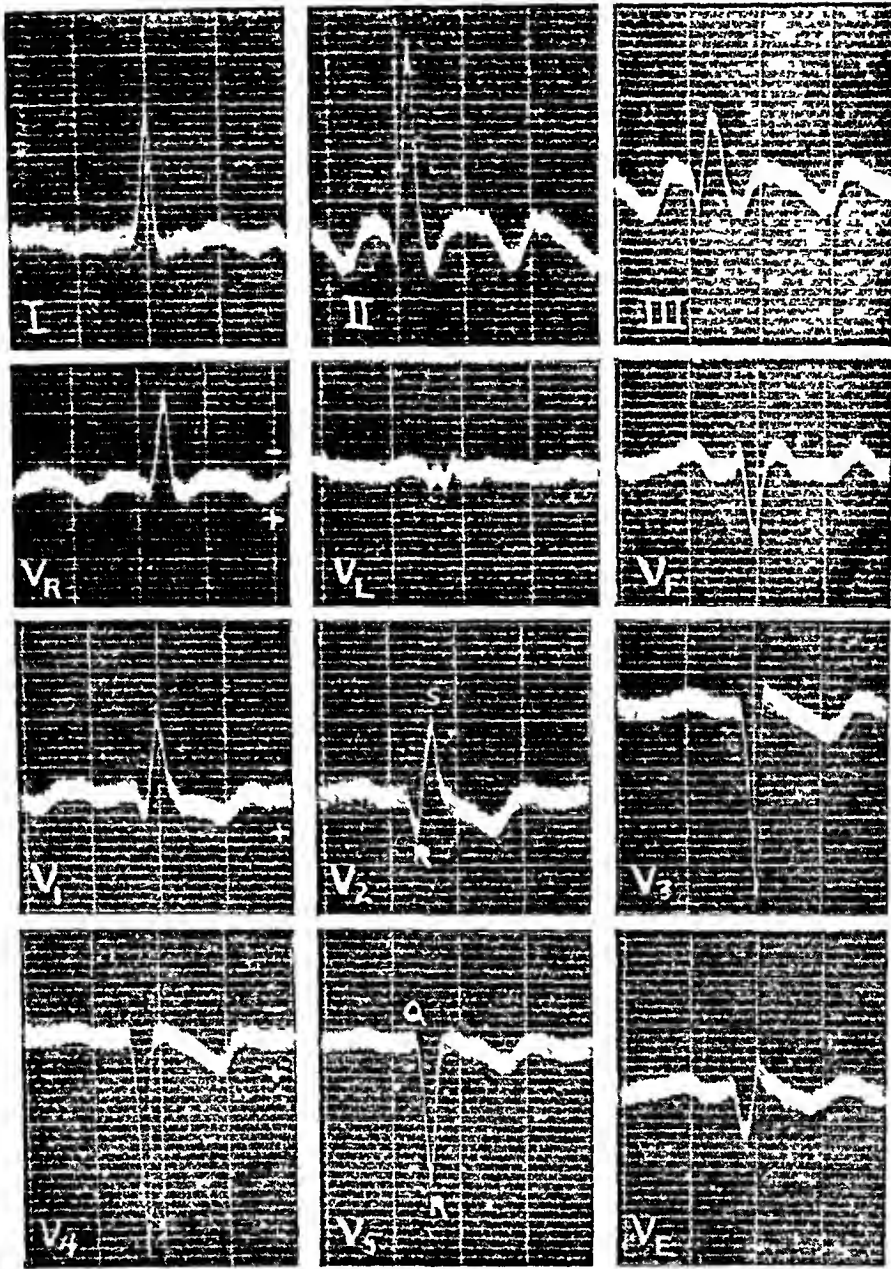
Standard leads (I, II, III) and the potential variations of the right arm (V_R), of the left arm (V_L), and of the left leg (V_F) recorded at normal string sensitivity on November 19, 1934. The last six tracings were recorded at half normal (1 cm = 2 mv) sensitivity, and represent the potential variations of the following precordial points: V_1 , fifth rib, right sternal edge; V_2 , fifth rib, left sternal edge; V_3 , fifth intercostal space, left parasternal line; V_4 , fifth intercostal space, left midclavicular line; V_5 , sixth rib, anterior axillary line; V_E , tip of ensiform. For the special leads a downward deflection represents positivity of the exploring electrode. Therefore, all deflections are labeled as though they were upside down. Time lines occur every 0.2 sec. The patient was receiving no medication.
